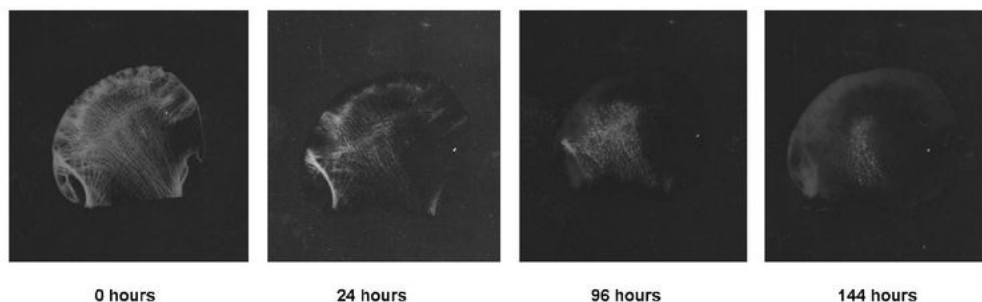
The process of decalcification. An X-ray series of a femoral head with formic acid/citrate decalcifier. The radiographs were produced using a Hewlett-Packard Faxitron® and allow the process to be accurately followed and the endpoint to be properly identified. Images adapted from Leica Biosystems.
